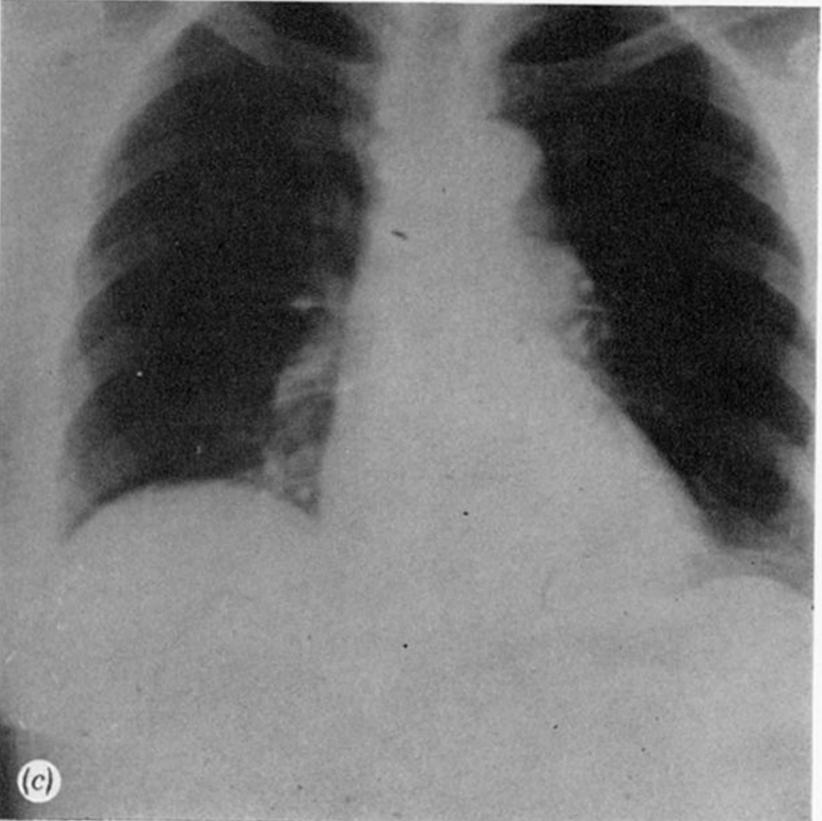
The classic situation seen in a patient with deep-vein thrombosis and pulmonary embolism: a positive uptake of iodine-125 fibrinogen in the left calf (a), wedge defects on the technetium-99m macroaggregated albumin perfusion scan (b) and a clear chest X-ray (c). Xenon-133 ventilation series was also normal.
